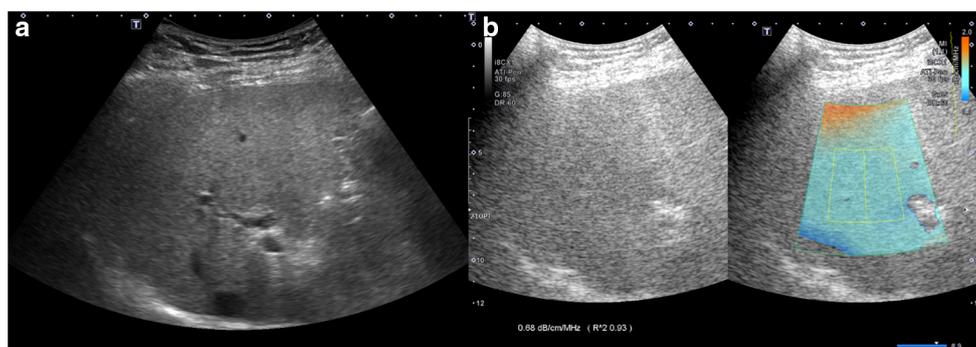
An example of an attenuation imaging (ATI) examination. After the acquisition of an adequate sonic window on the grayscale ultrasound image (a), an ATI examination was performed. b On the ATI examination, a conventional grayscale ultrasound image is shown on the left side and the same ultrasound image overlain with an attenuation map is simultaneously shown on the right side. The degree of attenuation
